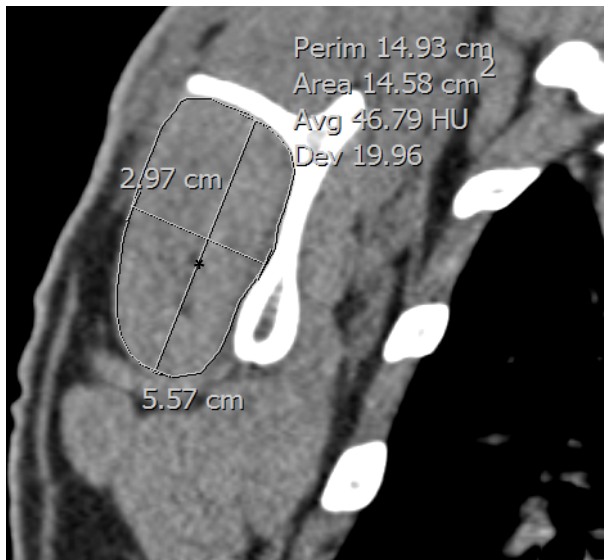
Coronal reconstructed CT image showing the four quadrants in the infrapsoas muscle. The muscle centre (*) in the coronal plane served as reference point for the transverse plane in order to conduct density measurements.
